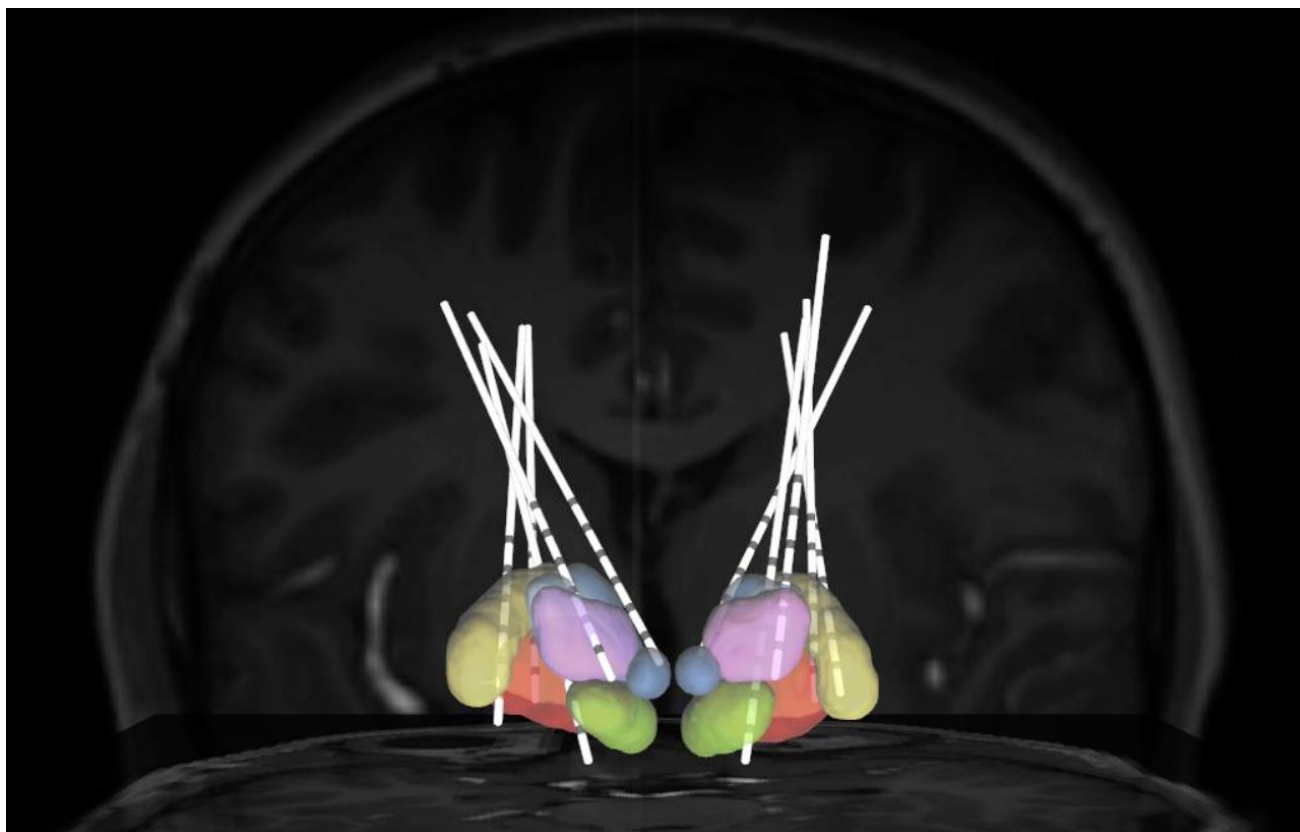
A 3D rendering based on co-registered CT and MRI images from an individual patient. Implanted sEEG electrodes are visualized in common target areas: VIM (pink), Voa/Vop (blue), STN (green), GPi (red), and globus pallidus externus (GPe, yellow).
